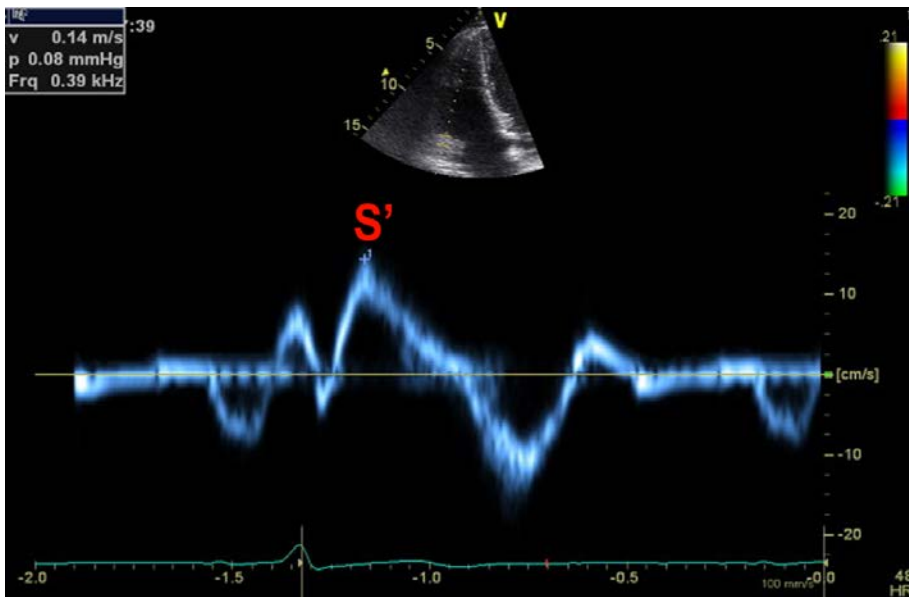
Recording the tricuspid annular peak systolic tissue velocity using pulsed-wave tissue Doppler imaging (RV PWTDE S').
